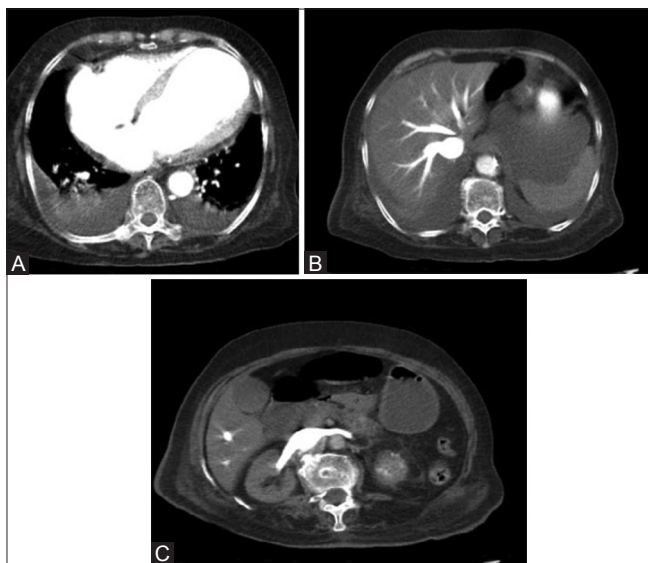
(A-C): (A) Contrast enhanced CT of abdomen. Most cranial axial section demonstrates uniformly enhancing cardiac chambers. (B) Axial image shows densely filled hepatic segment of inferior vena cava. Branching hepatic veins are also seen due to retrograde reflux. (C) Axial view demonstrates significant reflux into both renal veins from the inferior vena cava
